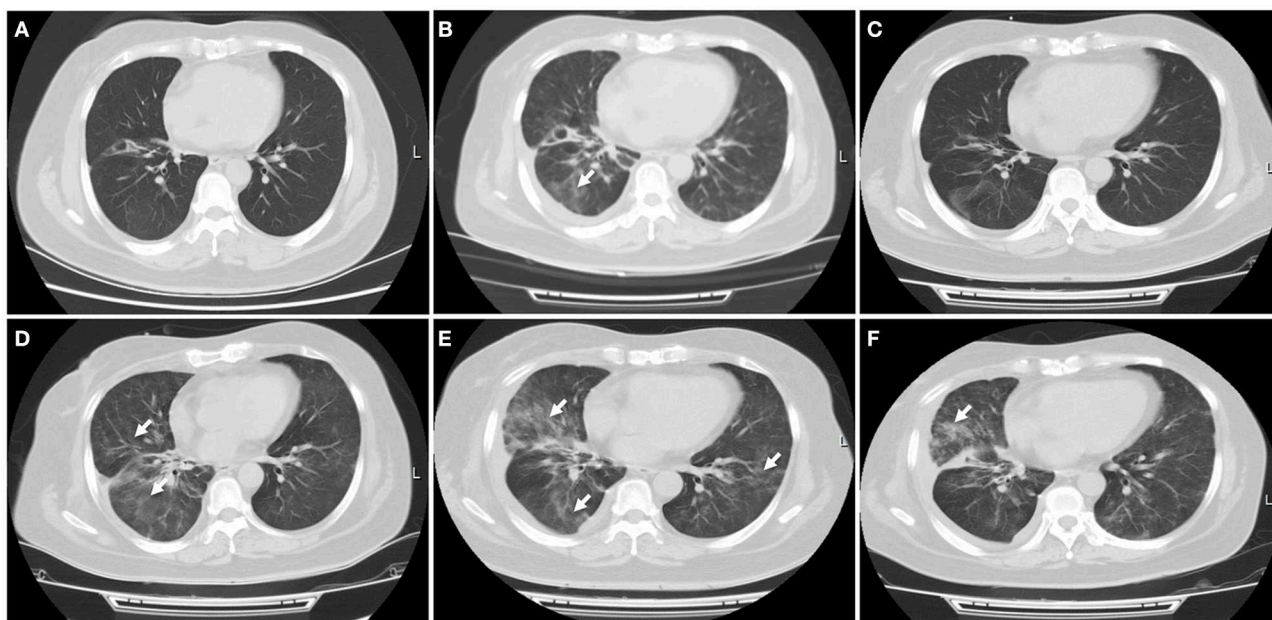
Immune-related pneumonitis. (A) A CT scan showed no any inflammatory lesions in the lungs following the treatment with first PD-L1 inhibitor atezolizumab. (B) Nivolumab was started when this patient progressed on atezolizumab treatment. A CT scan indicated new patchy ground-glass opacities in the bilateral lungs, with a small left pleural effusion. Immune-related pneumonitis was identified when blood and sputum culture did not reveal a causative microbial organism. (C) After treatment with corticosteroid for 1 week, this patient's symptom improved significantly, with a radiologic complete resolution of the ground-glass opacities and the pleural effusion. (D) Ten days later, a CT scan showed reoccurred pneumonitis, of grade 3 severity. (E) High-dose intravenous corticosteroid therapy did not alleviate her symptoms within 5 days, with worsening radiographic findings. (F) After she received immunosuppressive agents including infliximab, mycophenolate mofetil and human immunoglobulin, fever, dry cough, and dyspnea were relieved significantly, with a significant improvement of pulmonary inflammation. White arrow indicates inflammatory lesions.
